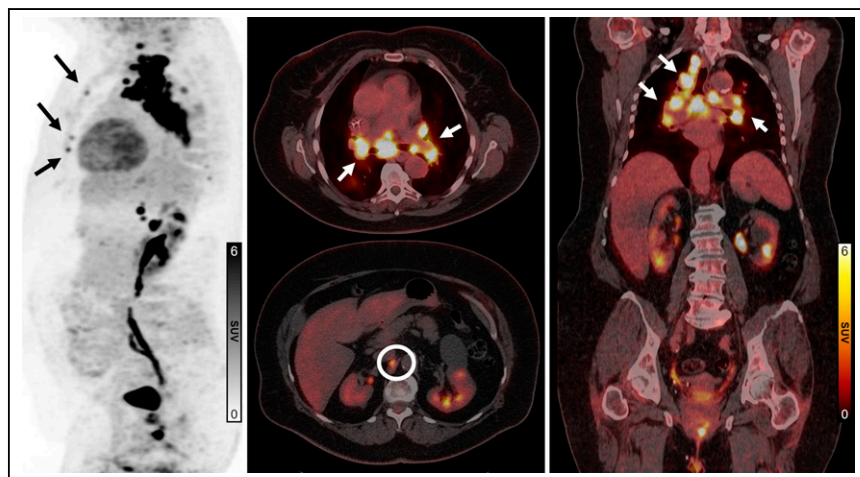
Scan 3 ^{18}F -FDG sagittal maximum-intensity projection (left), ^{18}F -FDG PET/CT fused axial (middle), and ^{18}F -FDG PET/CT fused coronal (right) views. Images show mediastinal, supraclavicular (white arrows), and retroperitoneal (circle) hypermetabolic lymphadenopathy with new or enlarged lymph nodes since scan 1, consistent with sarcoidosis with possible involvement of bilateral ribs (black arrows).
